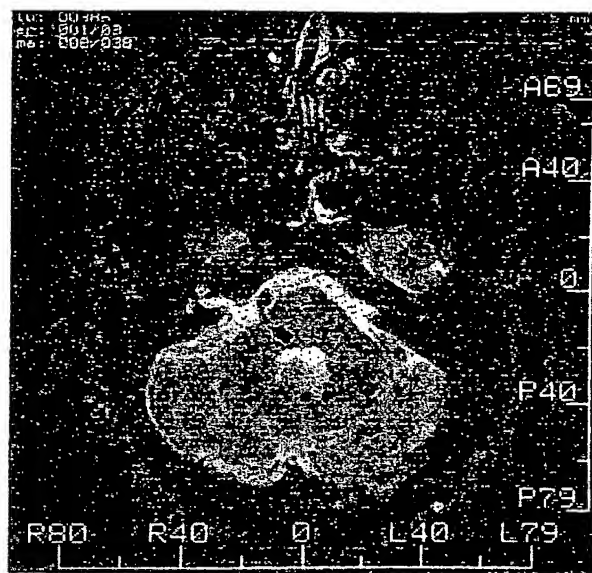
Magnetic resonance image of a 33-year-old man with a 6-month history of right hemifacial spasm. Arterial compression of the brain stem at the exit zone of the right facial nerve is shown (arrow).
